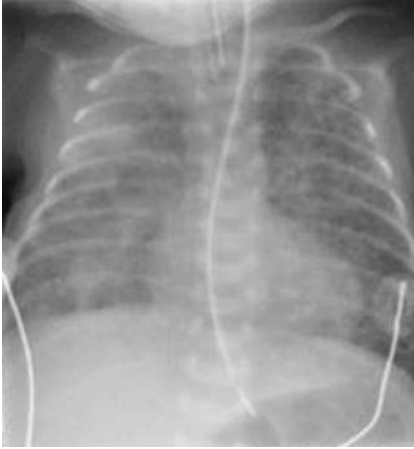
Chest radiograph of a ventilated infant with severe BPD.
